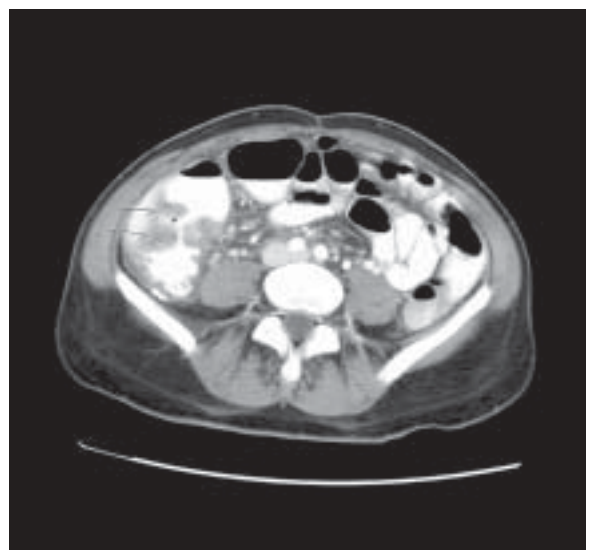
Colonic wall thickening. Contrast enhanced computed tomographic image demonstrates abnormal thickening of the ascending colon with characteristic “thumbprinting” (arrows).
